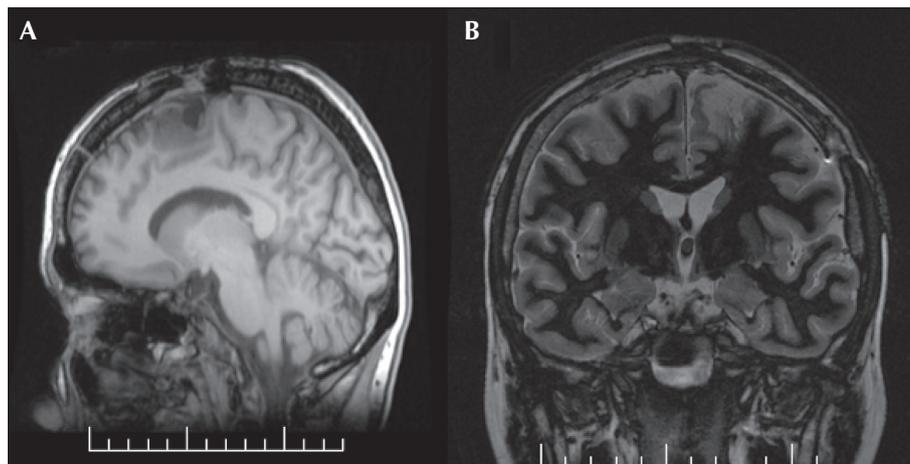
Postoperative MRI on sagittal (A) and frontal (B) slices.
